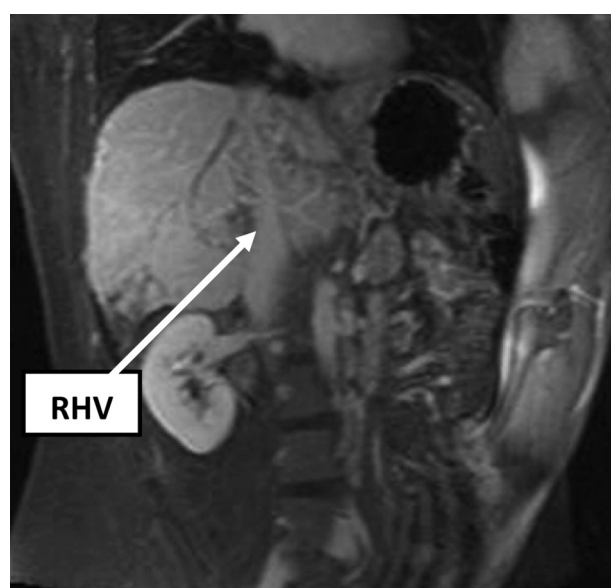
An extensively thrombosed right hepatic vein (RHV) on a coronal CT-scan.
